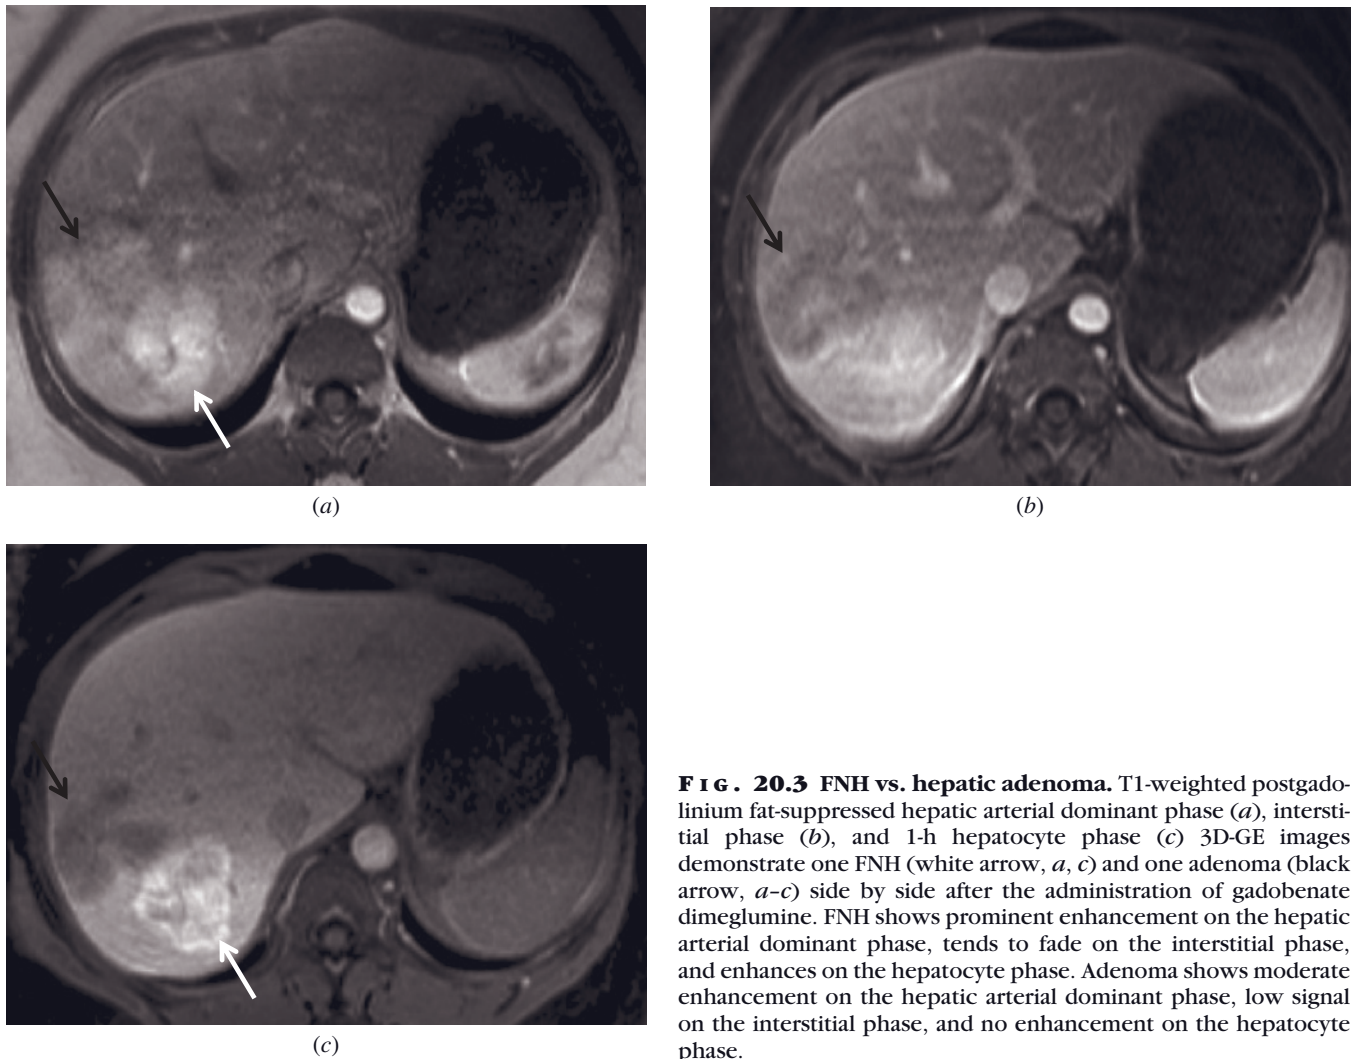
FNH vs. hepatic adenoma. T1-weighted postgadolinium fat-suppressed hepatic arterial dominant phase (a), interstitial phase (b), and 1-h hepatocyte phase (c) 3D-GE images demonstrate one FNH (white arrow, a, c) and one adenoma (black arrow, a-c) side by side after the administration of gadobenate dimeglumine. FNH shows prominent enhancement on the hepatic arterial dominant phase, tends to fade on the interstitial phase, and enhances on the hepatocyte phase. Adenoma shows moderate enhancement on the hepatic arterial dominant phase, low signal on the interstitial phase, and no enhancement on the hepatocyte phase.
